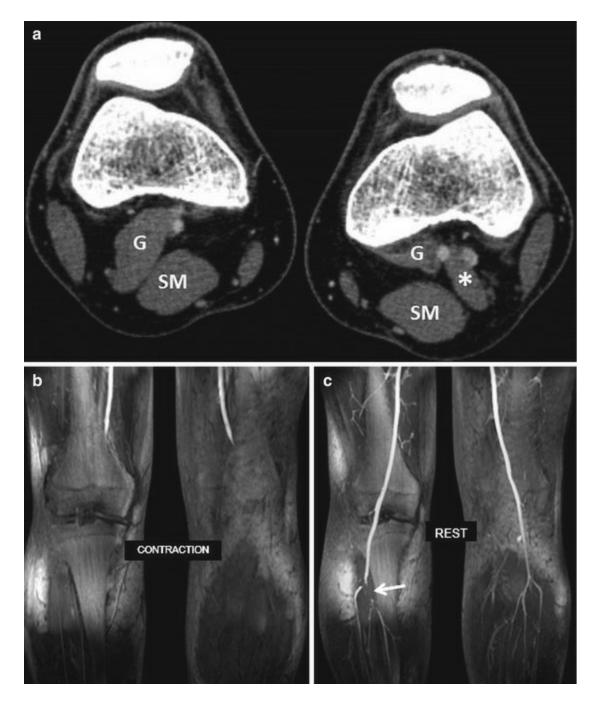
A 29-year-old male patient with a history of subacute ischemia of the right leg and bilateral popliteal artery entrapment syndrome. Axial CT image (a) of the knees shows abnormal anatomy of the popliteal fossa with vascular enhancement. On the right side, medial gastrocnemius (G) travels laterally to popliteal vessels, resulting in a type 5 PAES. Semi-membranosus (SM) is visible superficially. On the left side, an accessory slip (asterisk) of the medial gastrocnemius lies between popliteal artery and vein, resulting in a type 3 PAES. Coronal MR angiography reformatted maximum intensity projection images (b, c) demonstrate complete stenosis of the proximal popliteal artery during contraction (b) of the triceps surae. At rest (c) residual stenosis of the tibiofibular trunk and proximal anterior tibial arteries is visible (arrow), resulting from a past acute thrombosis (Image courtesy of Dr. Antoine Larralde, University Hospital, Rennes, France)
